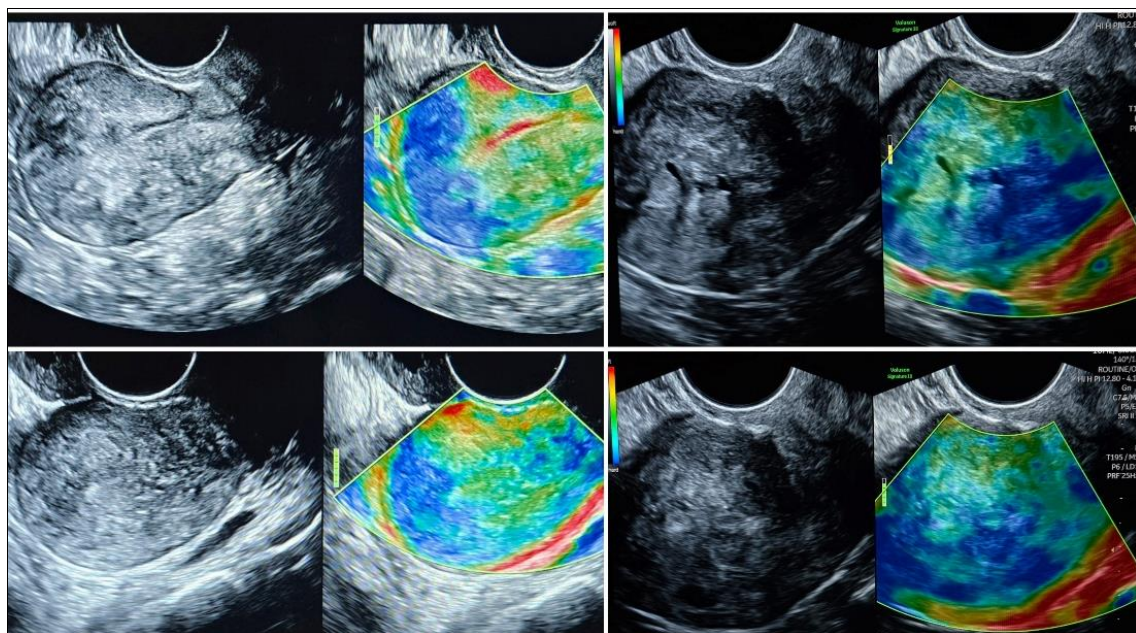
Grayscale transvaginal ultrasound (left) of adenomyotic uterus demonstrating heterogeneous myometrial echotexture and corresponding strain elastography image (right) showing blue areas(stiffer) within the Green to yellow myometrium(softer).
